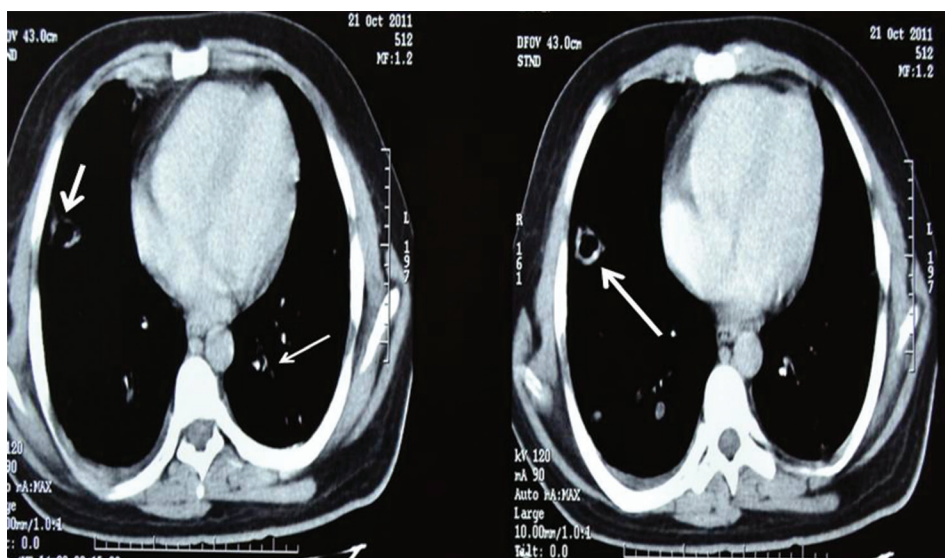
Thoracic computed tomography shows bilateral recurrent pulmonary embolic events in an intravenous drug user patient (White arrows)
